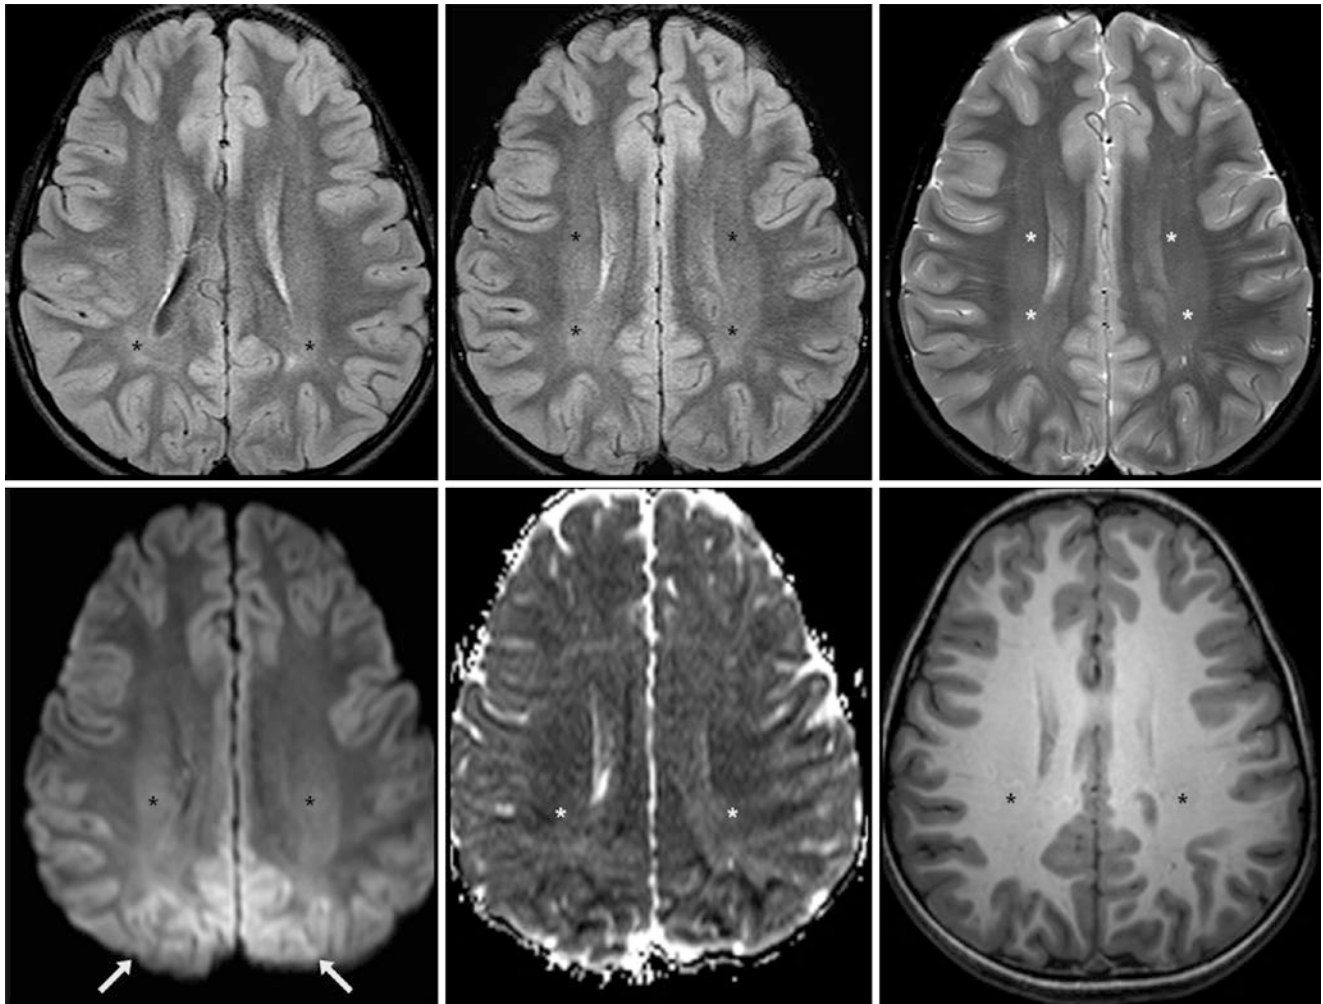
A 9-year-old with migraines had a negative 3 T MRI that demonstrated mild PVWM hyperintensity (*asterisk*) on FLAIR (*top left and top middle*), which is slightly less prominent on T2WI (*top right*), and DWI (*bottom left*). Although there is mild PVWM hyperintensity on DWI, the corresponding ADC map (*bottom middle*) and gradient
